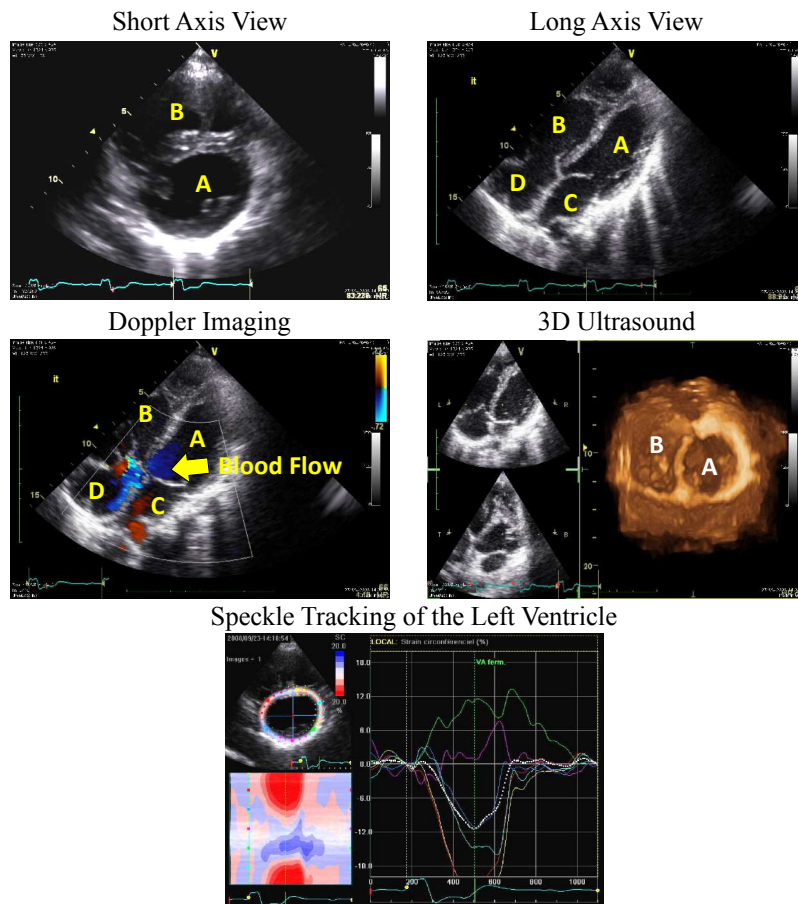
Echocardiography of a patient with repaired tetralogy of Fallot. A- Left ventricle. B- Right ventricle. C- Left atrium. D- Right atrium (*Images from APHP, Necker-Enfants Malades, Paris*).
